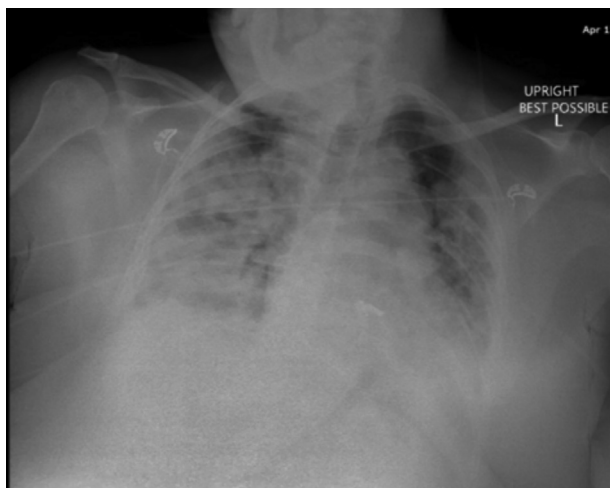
Chest X-ray with multispace air opacities.
